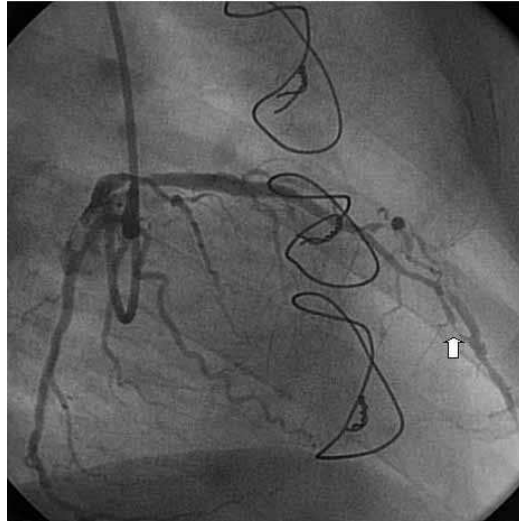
A stenosis (arrowed) is recognised in the x-ray diagnostic images as a constriction of the residual lumen. (Image courtesy of Catharina Hospital Eindhoven)
